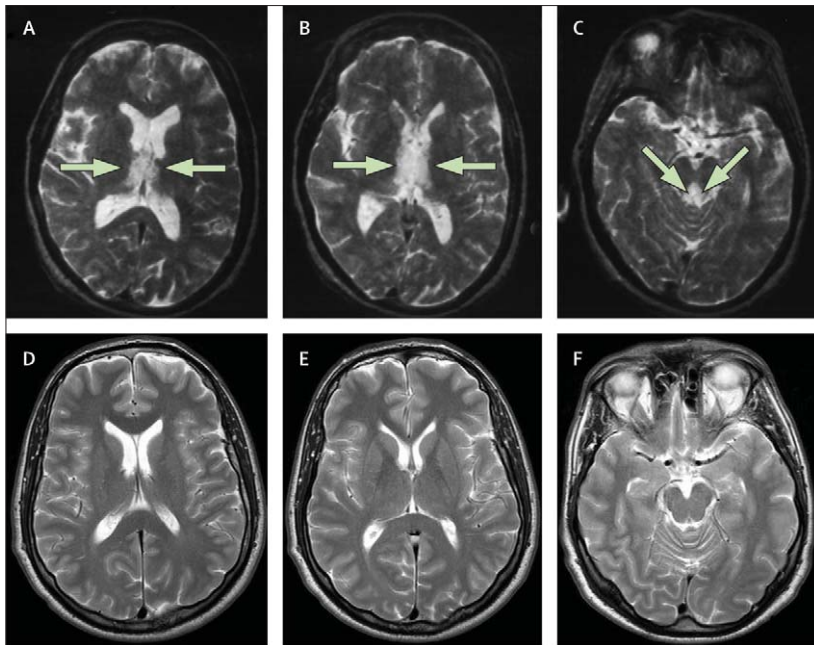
T2-weighted axial MRI in Wernicke's encephalopathy
